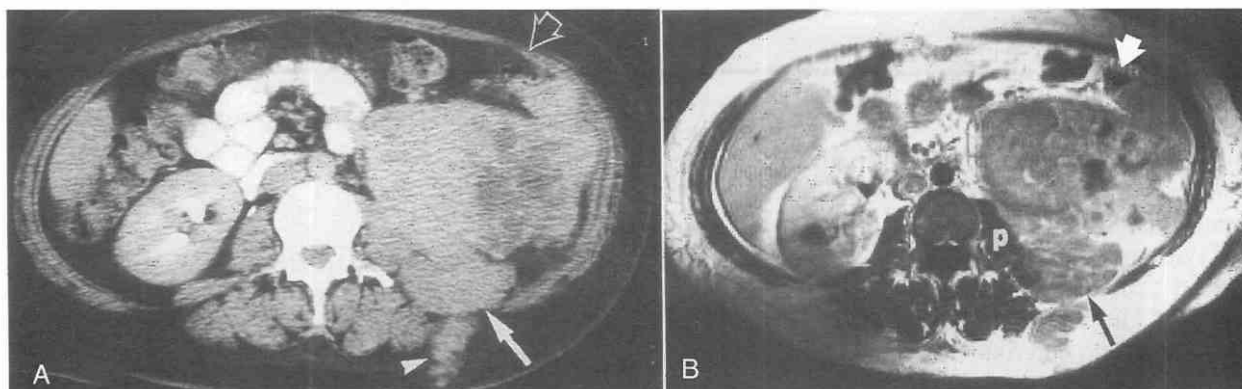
Left renal cell carcinoma with extension beyond the renal fascia. *A*, The tumor invades the abdominal wall in the region of the left quadratus lumborum muscle (*arrow*). Tumor has grown along a needle biopsy track in the subcutaneous tissues (*arrowhead*). Tumor invasion of the descending colon (*open arrow*) was confirmed at surgery. Although the neoplasm abuts the left psoas muscle, there was no actual muscle invasion. *B*, Contrast-enhanced MR image (spin-echo, TR = 500 msec, TE = 15 msec) reveals that the neoplasm does not invade the psoas muscle (*p*). However, tumor has invaded the abdominal wall (*long arrow*) and the colon (*short arrow*).
